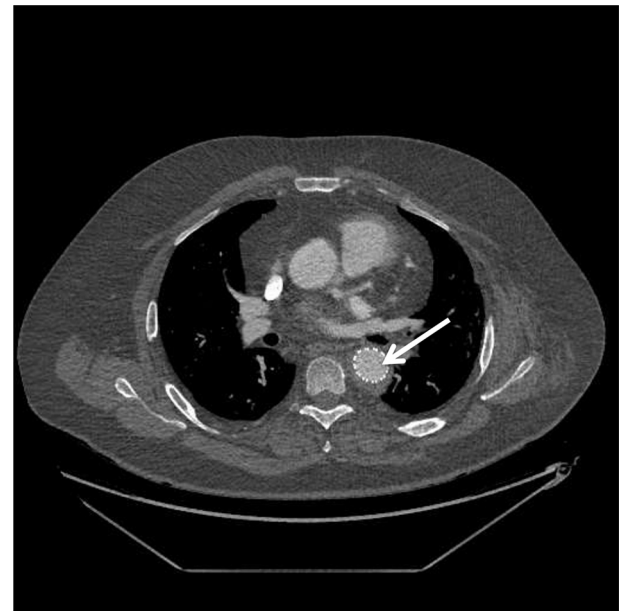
CT image of the chest showing thoracic endovascular aneurysm repair successfully excluding the aortobronchial fistula. (White arrow – endovascular stent graft).
